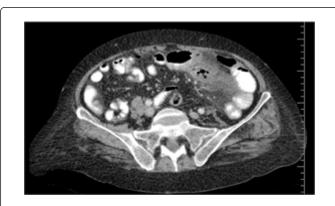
Abdominal computed tomography of case 2, elevation of density of the jejunal mesentery that contained extraluminal air and localized fluid around this jejunal segment.
